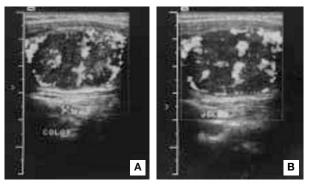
Color flow Doppler sonography of right thyroid nodule, performed on L-T<sub>4</sub> therapy (A) displayed increased blood flow in peripheral and intranodular tissue (type III pattern). Features observed off L-T<sub>4</sub> therapy (B) showing a pattern indistinguishable from that shown in Figure 1A.
